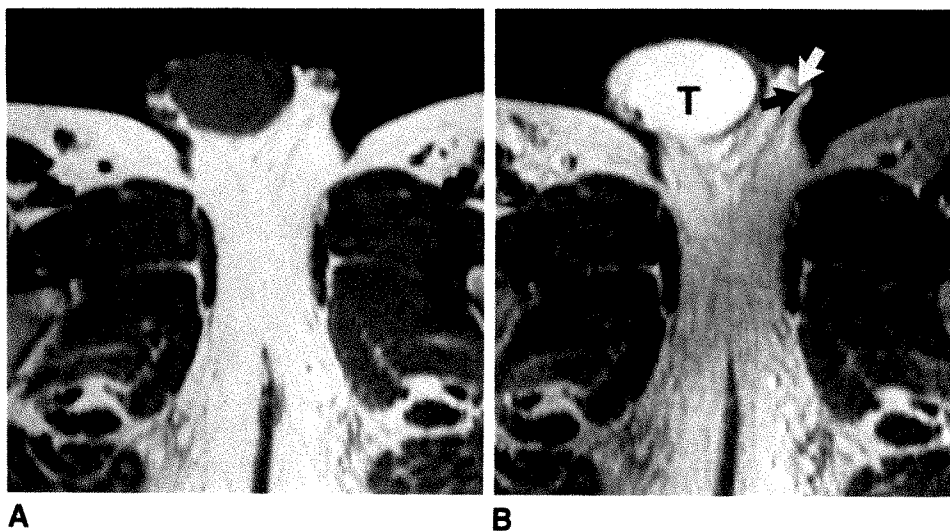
Axial MR images of pars infravaginalis gubernaculi show nonpalpable left testis in 5-year-old boy.
